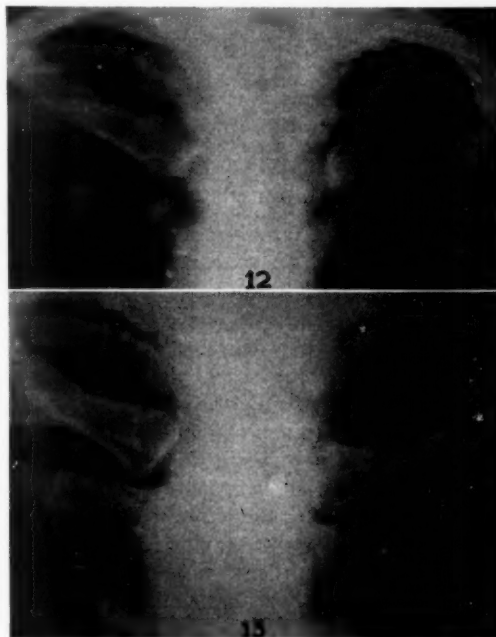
Case 5. Roentgenogram taken June 9, 1926. Note small cavity in left apex with two small calcified lesions.
